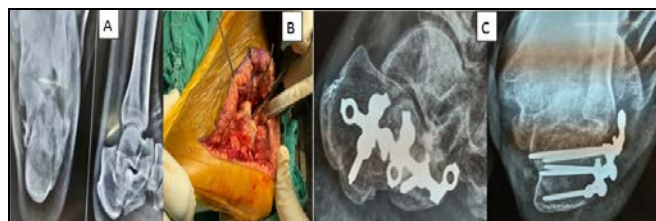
Axial view of calcaneus showing varus collapse & Lateral radiograph showing joint depression type fracture, Fig.1B – Intra-op photograph showing full thickness periosteal-cutaneous flap retracted with help of K- wires and elevation of depressed posterior articular fragment with help of curved osteotome, Fig.1C- Follow-up Lateral radiograph showing well maintained posterior articular facet and axial radiograph showing good alignment.
